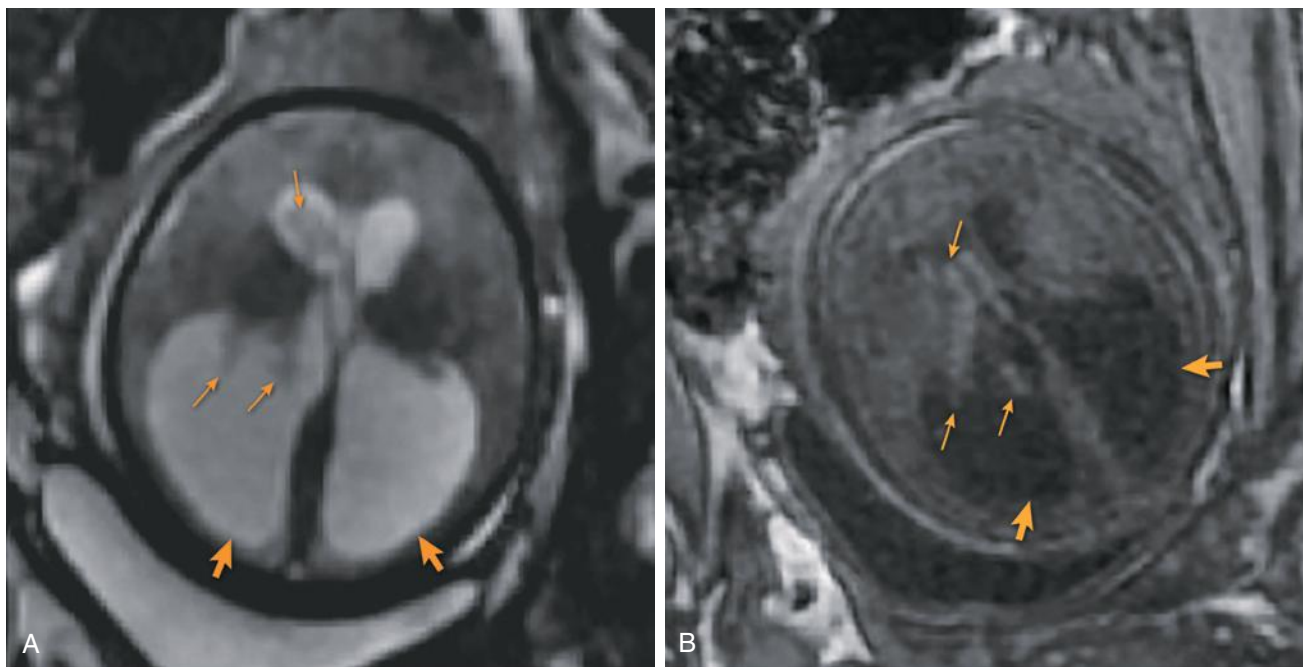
Intracranial hemorrhage causing new-onset hydrocephalus at 34 weeks' gestation. A, Axial balanced steady-state image with dilated lateral ventricles (*bold arrows*) and thrombus shown in right lateral ventricle (*small arrows*). B, Axial T1-weighted imaging bright signal in right germinal matrix and in dilated right lateral ventricle (*small arrows*) consistent with hemorrhage.
